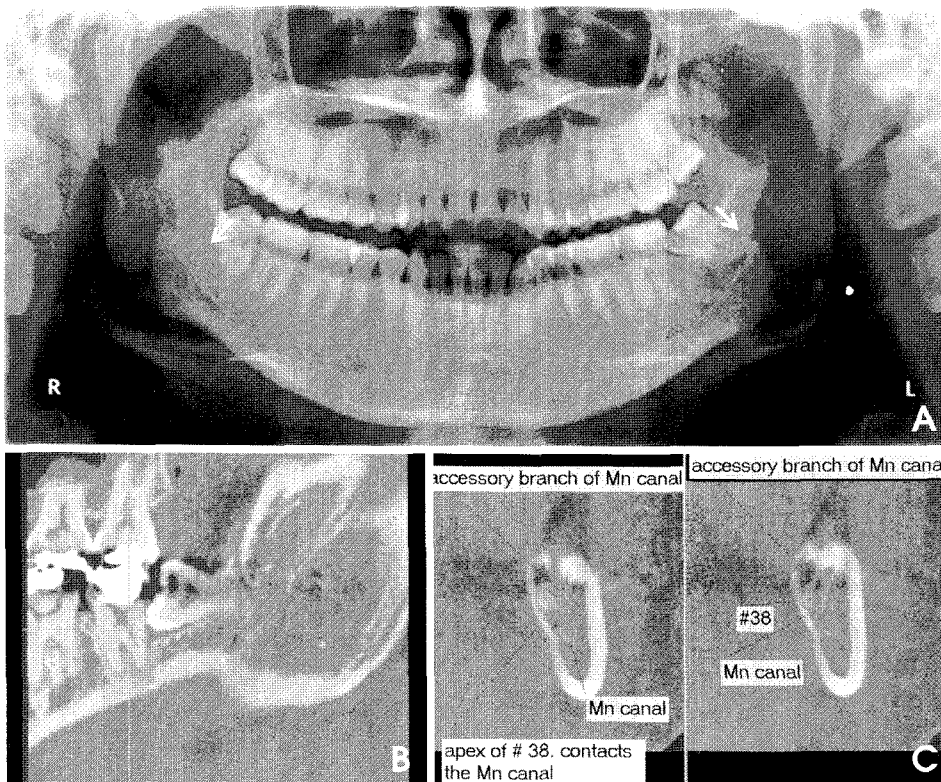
A, Panoramic radiograph shows left bifid mandibular canal (branch canal) near the root of the left mandibular third molar. B, C, Panoramic and cross-sectional CT images on dental program. The upper branch canal is narrow and running beneath the roots (#38).
